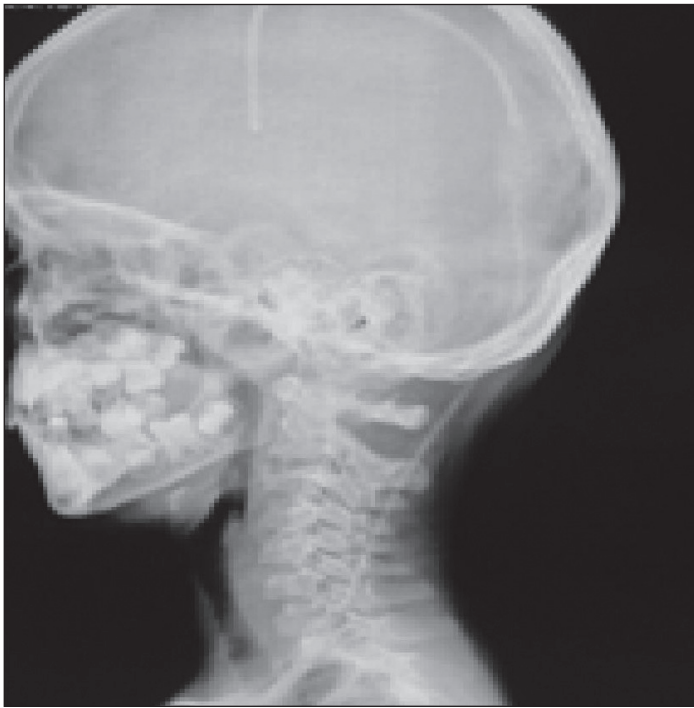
Cervical x-ray showing completed solid fusion .
